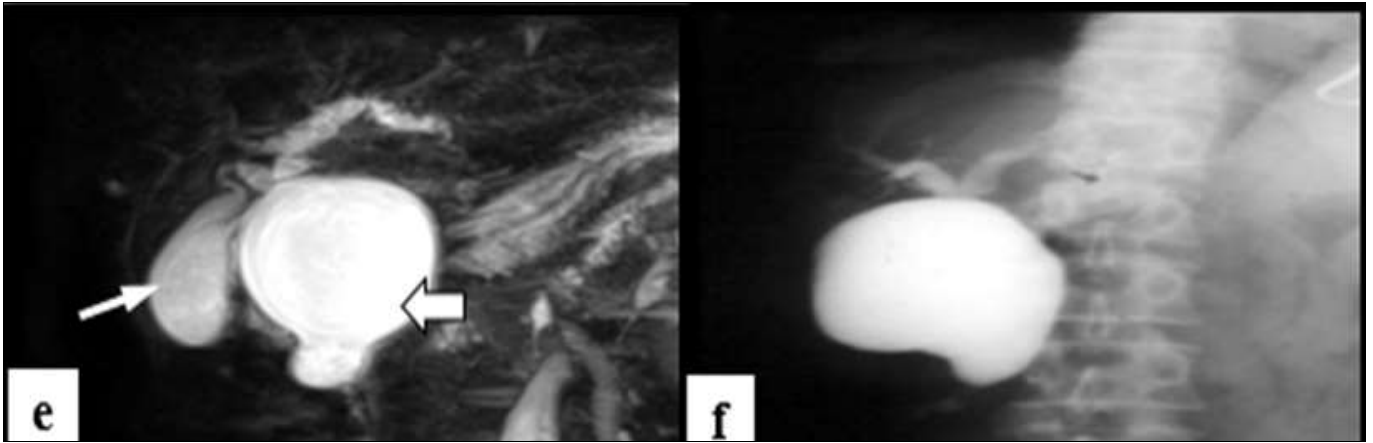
Female patient aged 25 years complaining from right upper quadrant pain and jaundice. Abdominal ultrasound (a) shows non vascular cystic structure at porta hepatis region that communicates with bile duct and is separate from gall bladder. Axial T2 weighted MR image (b), Coronal T2 weighted MR image (c), Coronal oblique 2D MRCP (d) & Coronal oblique 3D MRCP (e) show large cystic dilatation of the entire of CBD (thick arrow) about 5.8X6.2 cm in maximum diameter associated with mild dilatation of CHD, right and left main hepatic duct and normal distended gall bladder (thin arrow). Intraoperative cholangiography (f) shows cystic dilatation of CBD associated with mildly dilated CHD, right and left main hepatic ducts.
